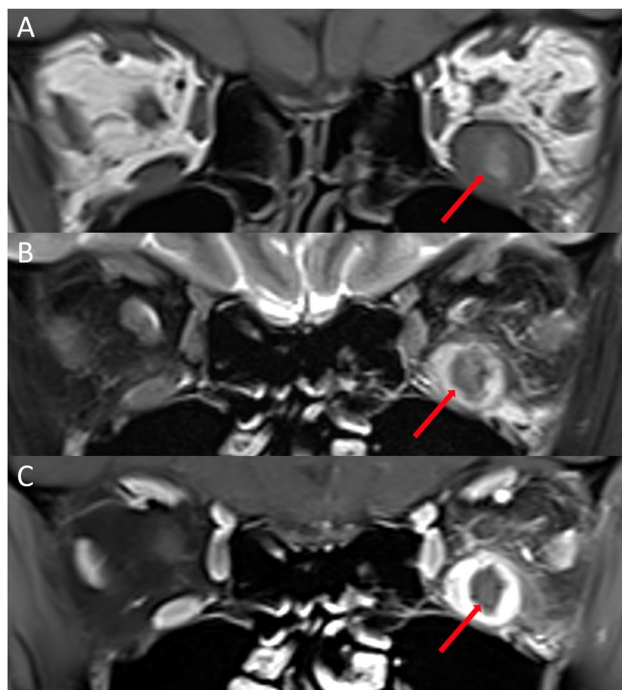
Melanoma metastasis. An axial T1-weighted MRI (A) shows isointense nodular enlargement of the right medial rectus muscle without involvement of the anterior tendon. An axial, contrast-enhanced, fat-suppressed T1-weighted image (B) through the superior orbit shows an area of central hypointensity (arrow) with increased peripheral rim enhancement. Coronal T1-weighted MRI (C) shows
